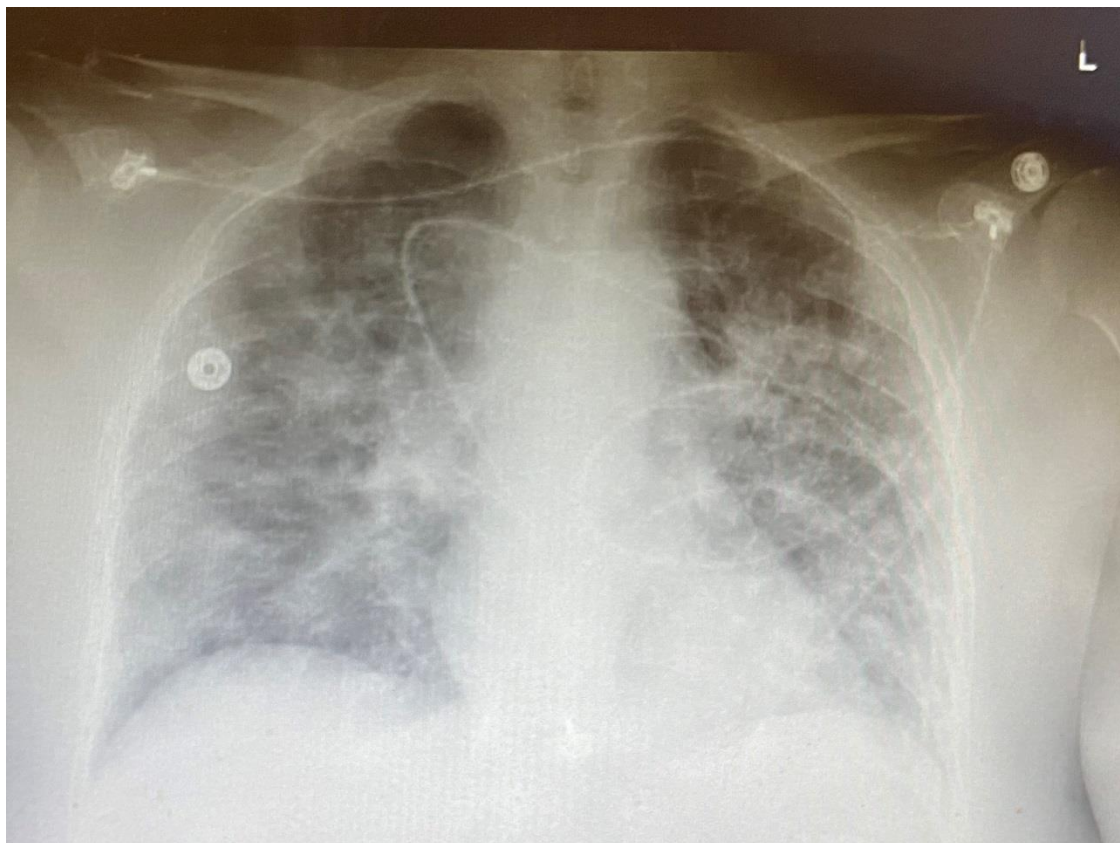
Day #13, chest x-ray 36 hours after hospital admission with worsening bilateral pulmonary infiltrates
